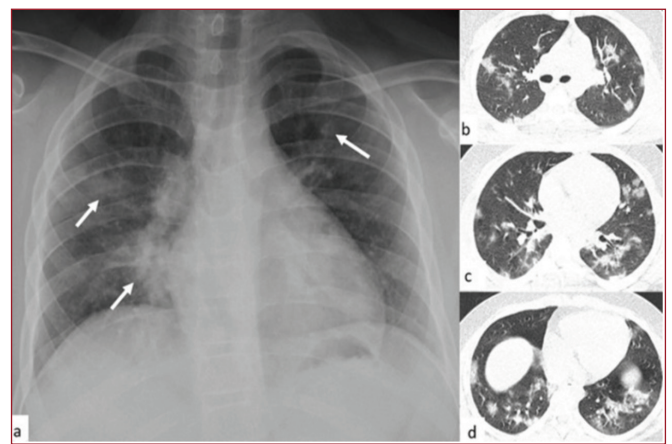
Posteroanterior chest X-ray and non-contrast axial CT section parenchymal window in a 15-year-old boy: Diffuse peripheral and peribronchovascular ground glass and consolidation areas in all zones of the bilateral parenchyma at lung-X-ray (a, arrow), and in the upper lobes (b), and in the middle lobe of the right lung and bilateral lower lobes (c, d) at computed tomography
